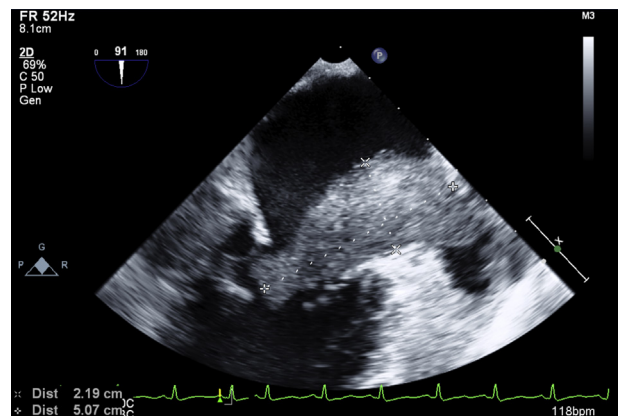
Transesophageal echocardiogram (TEE) mid-esophageal window, two-chamber view showing left atrial mass with significant growth (5.1×2.2 cm) compared with the previous TEE 6 weeks ago. There is prolapse of the mass into the left ventricle during systole resulting in obstruction of the mitral valve.
